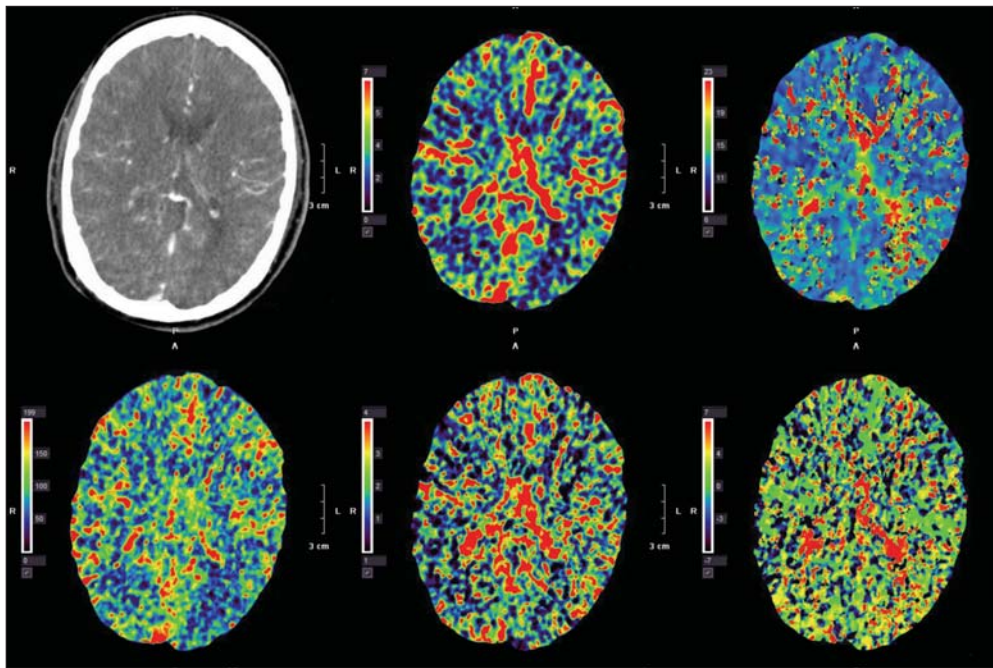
Normal computed tomographic perfusion (CTP) imaging study. Upper left, noncontrast head CT scan without evidence of any abnormality. Notice the symmetry in color for each component of the CT perfusion maps (remaining images), indicating normal flow without any evidence of large-vessel occlusion.
